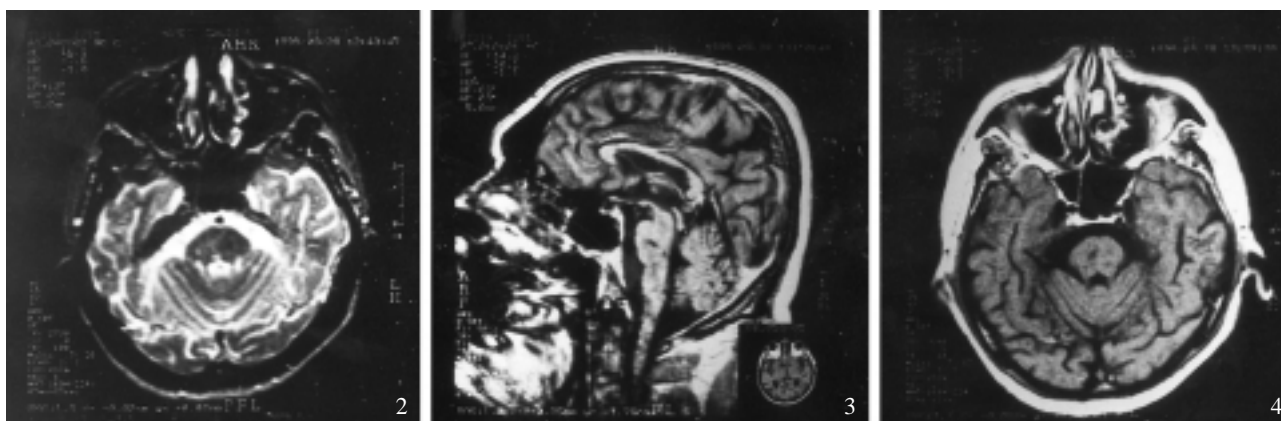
Brain MRI demonstrated pontine midline-right sided infarct on T2-weighted axial, T1-weighted axial and sagittal images.
